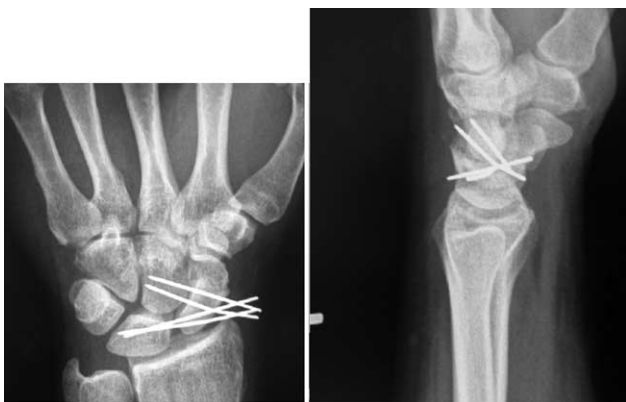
(A) Posteroanterior and (B) lateral radiographs of the same patient as in Figures 1 and 2 (patient 8) showing the placement of 1.4-mm K-wires across the SL and scaphocapitate intervals. Note the absence of a dorsal intercalated segment instability deformity on the lateral radiograph.
